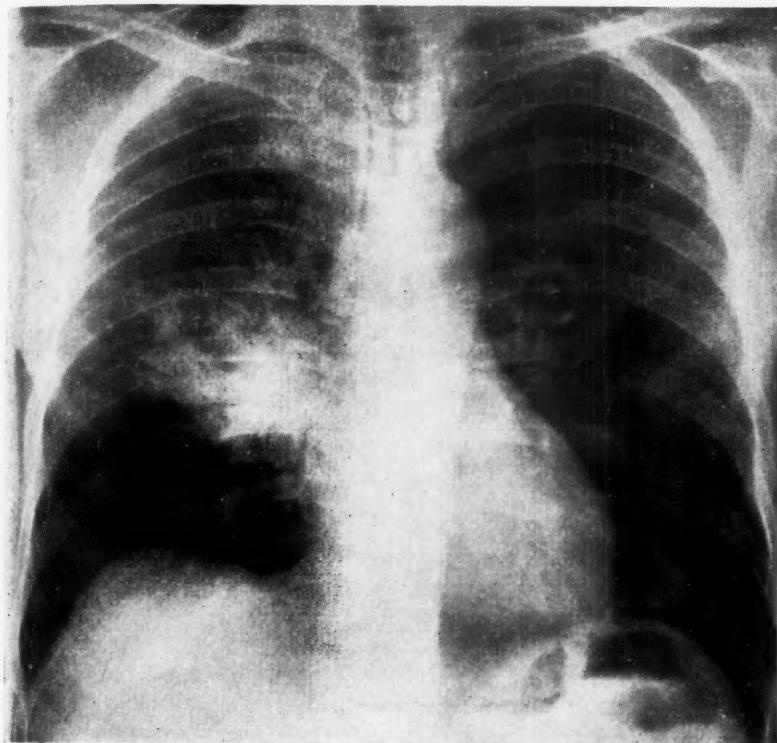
Chest x-ray in case 13 on Jan. 18, 1960
